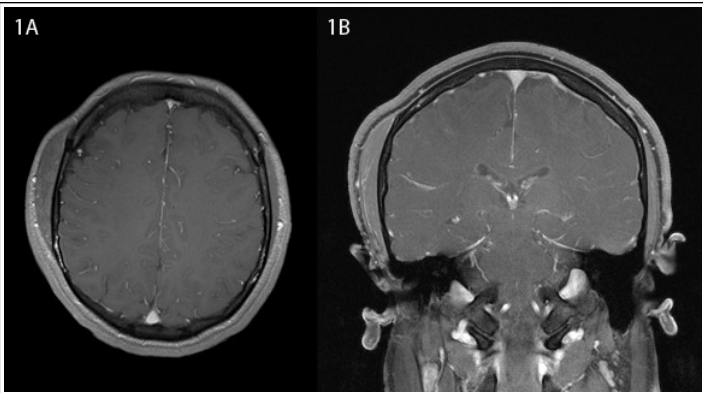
axial (1A) and coronal (1B) contrast cranial MRI demonstrating an enlarged nonenhancing right temporalis muscle
